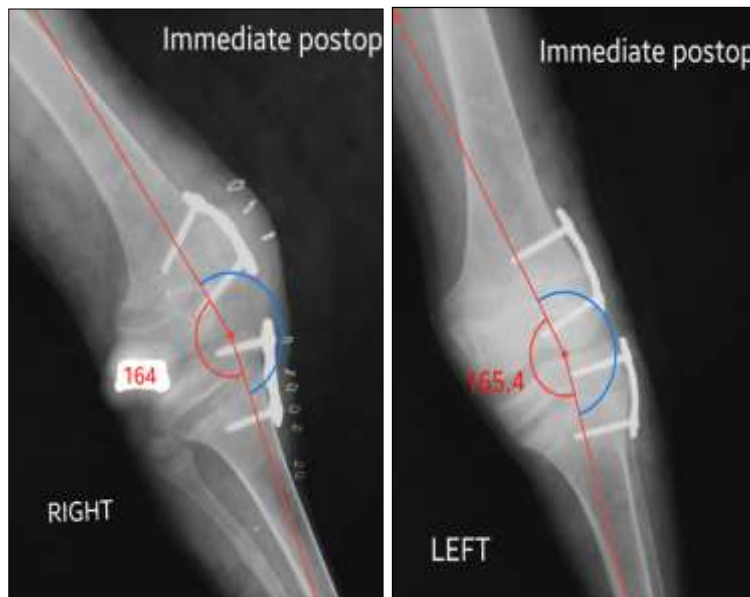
Immediate Postop AP Xray of both knee showing Medial Epiphysiodesis for Right Genu Valgum & Lateral Epiphysiodesis for Left Genu Varum.
